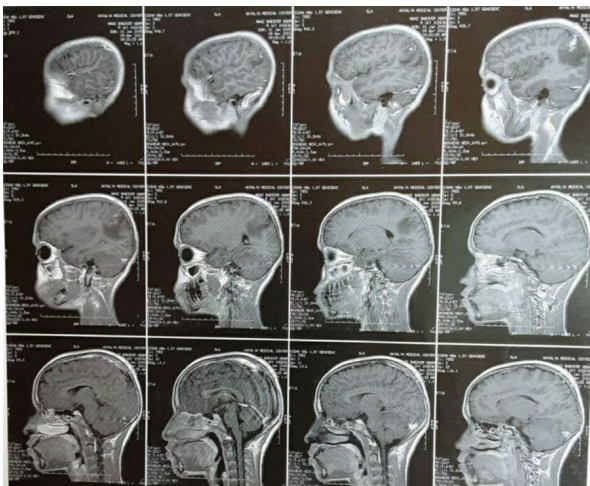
MRI brain T1 weighted image with contrast, sagittal cut shows the metastatic carcinoma in the occipital region and the small parietal parasagittal incidentally found meningioma.
